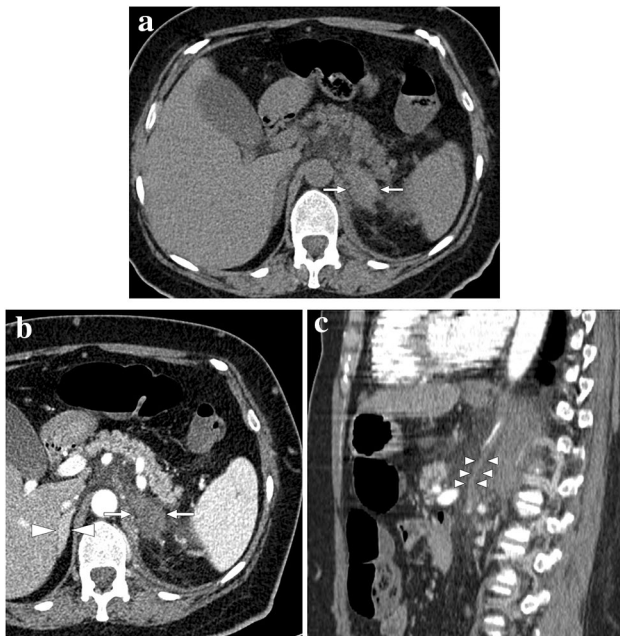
A 47-year-old female with known long-standing antiphospholipid antibody syndrome and systemic lupus erythematosus presented with acute onset of intense left flank pain. a Axial plane precontrast abdominal CT showed enlarged, mostly hyperdense-appearing left adrenal gland (arrows). Also, note was made of striations within the adjacent fat planes. b There was no discernible enhancement within the adrenal gland after IV contrast injection (arrows). The right adrenal gland was normal (arrowheads). c Sagittal plane reformatted CT image of the same study demonstrated a vertically oriented, tubular structure that was thought to represent the thrombosed left adrenal vein (arrowheads). The constellation of imaging findings was found to be consistent with hemorrhagic adrenal infarction
